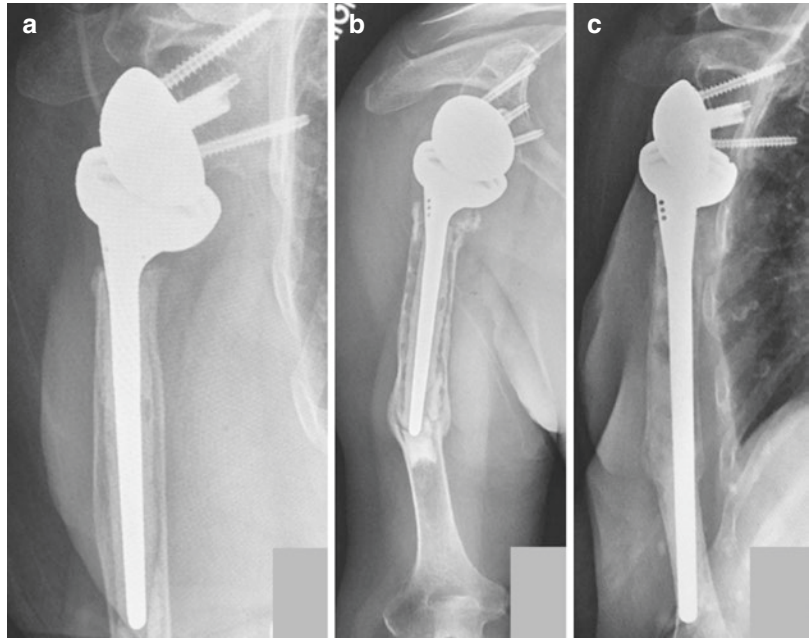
(a) Immediate postoperative radiograph of a lateralized RSA. (b) early component loosening at 6-week follow-up in a large patient, with a well-placed glenosphere, but a lateralized design
